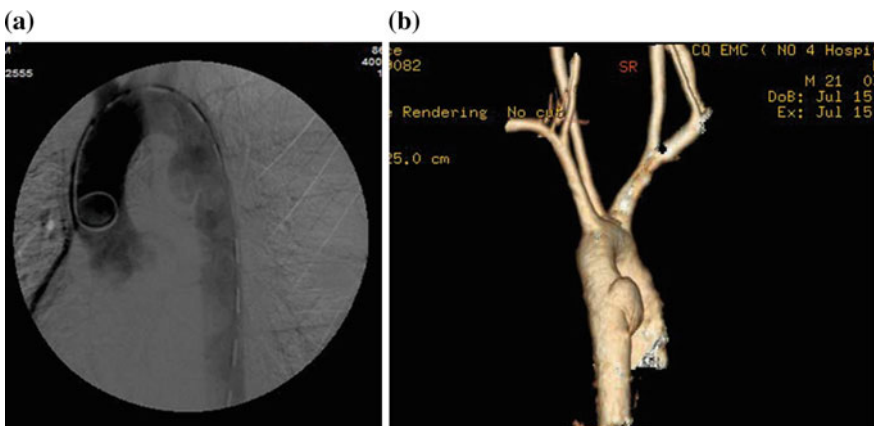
A multiple trauma patient, male, 21 years-old, was impacted by traffic accident. The DSA (a) and CTA (b) examination showed traumatic aortic injury (TAI)
